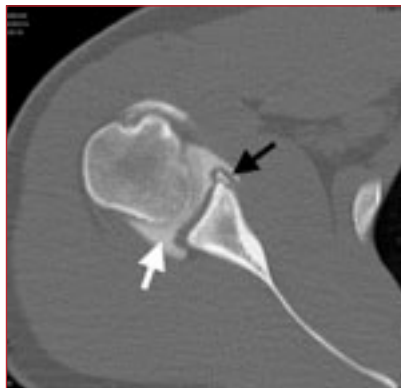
CT arthrogram of the shoulder demonstrating Bankart lesion of anterior glenoid (black arrow). Note contrast in joint space (white arrow).
